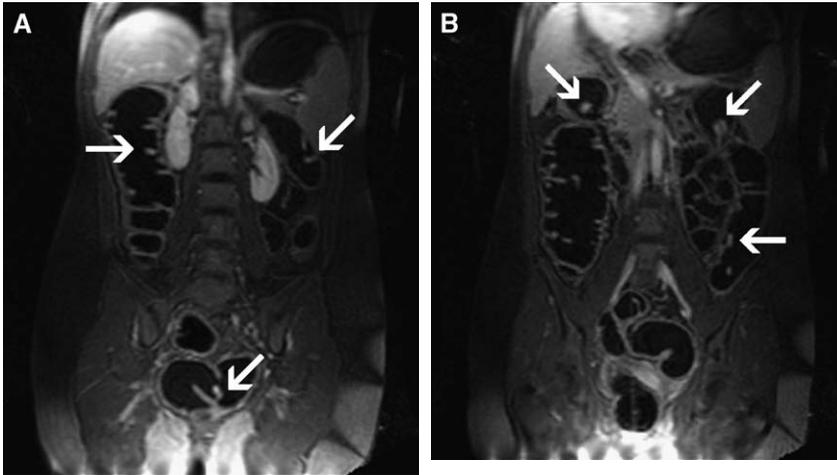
(A, B) Patient who has polyposis coli. Multiple colorectal polyps (*arrows*) are shown on the contrast-enhanced T1-weighted data sets.
